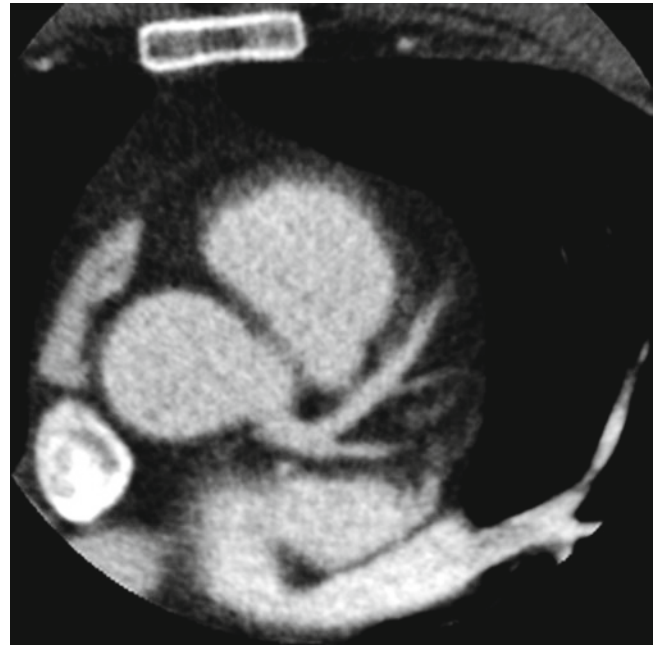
Coronary CT angiography by EBCT. This contrast-enhanced transaxial image shows the proximal left main, left anterior descending, and left circumflex coronary arteries (3.0 mm slice thickness, 100 ms acquisition time)
